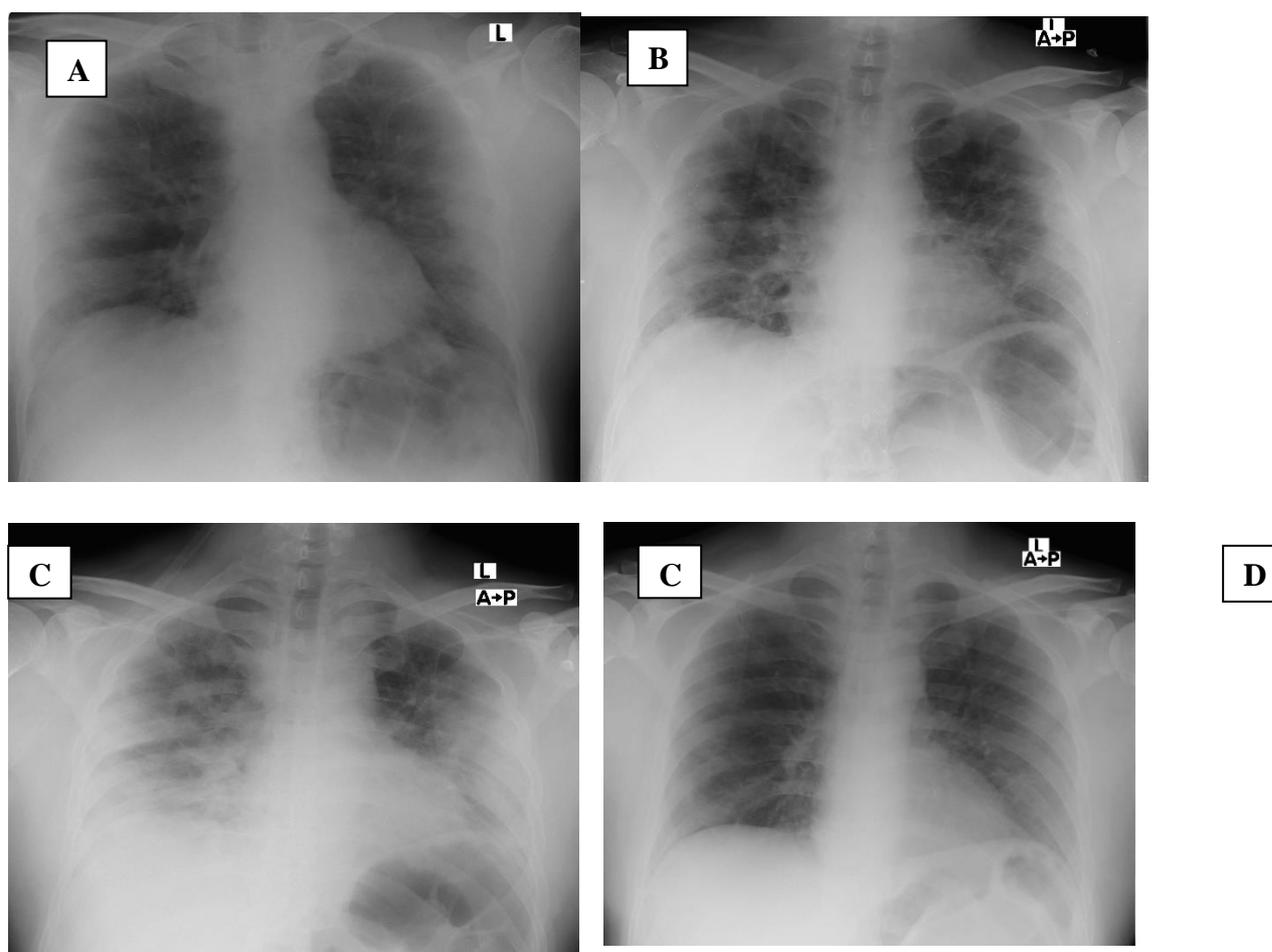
Degree of lung involvement on CXR: Initial CXR and series of follow up x-rays of a COVID-19 patient who received ICU care and recovered demonstrate CXR changes along the course of illness: A- Initial chest X-ray after admission (Severity score-2); B-Follow up chest X-Ray demonstrating bilateral patchy consolidation (Severity score-6); C- Follow up chest X-ray demonstrating worsening consolidation (Severity score-8); D- Recovery phase chest X-ray (Severity score-2).
